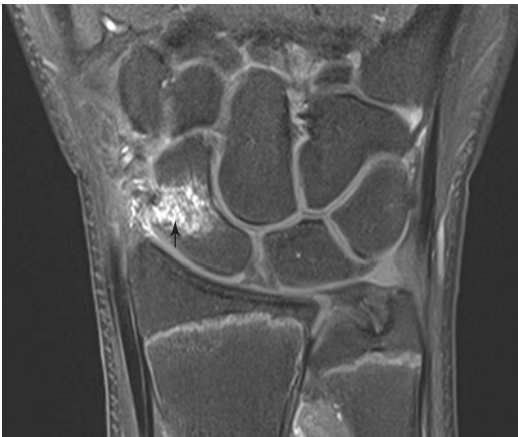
Axial PDf MRI: detection of a trabecular microfracture of the scaphoid with hyperintense blurred fracture zone
